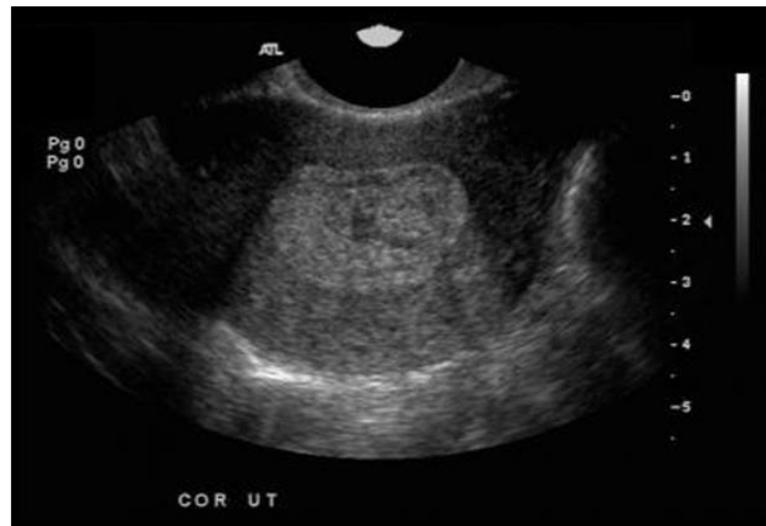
5): sonogram shows a markedly heterogeneous and thickened endometrium, a finding that is compatible with endometritis.
